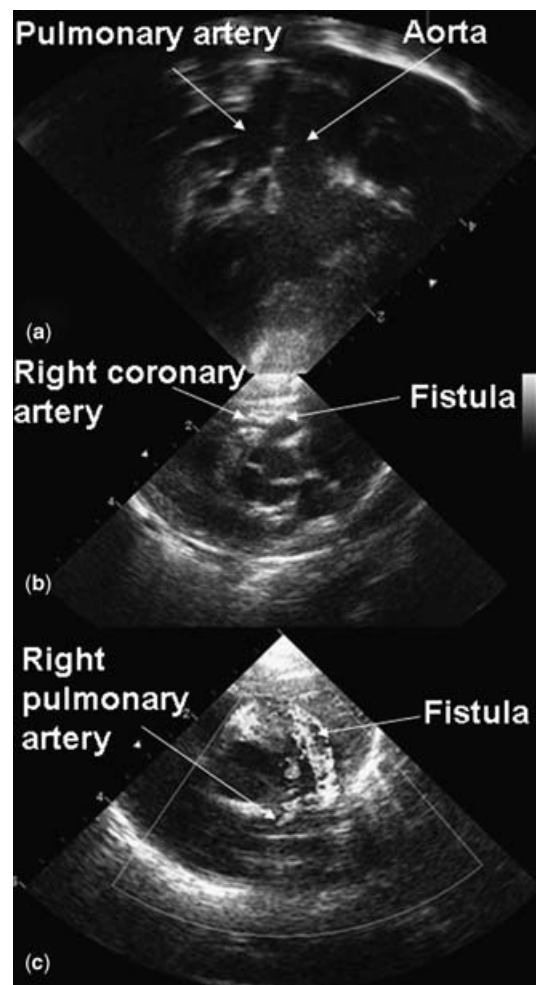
Echocardiographic views showing sub-pulmonary obstruction with normal connection between the right ventricle and the main pulmonary artery (a), a fistula arising from the right coronary artery (b), and connecting with the right pulmonary artery (c).
